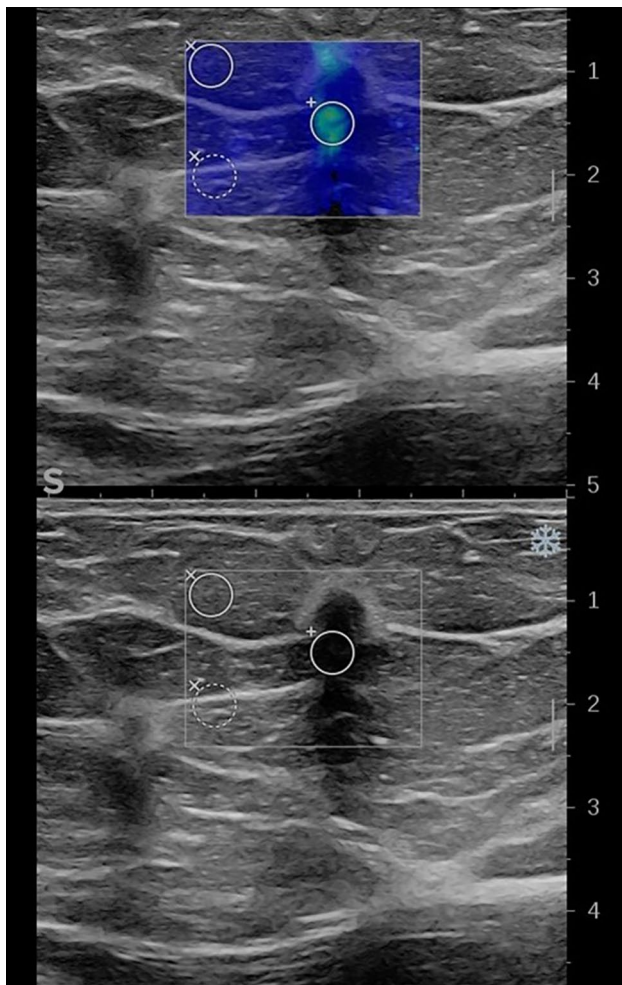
B-mode ultrasound shows a small hypoechoic mass with irregular margins and posterior acoustic shadowing. Ultra-fast SWE shows in the colorimetric map a significant increase in the stiffness of the peripheral tissue, also supported by the numerical values of the ratio between kPa suspicious tissue/kPa healthy tissue (kPa ratio 7.31). The lesion resulted to be a non-special type invasive breast cancer (B5)
